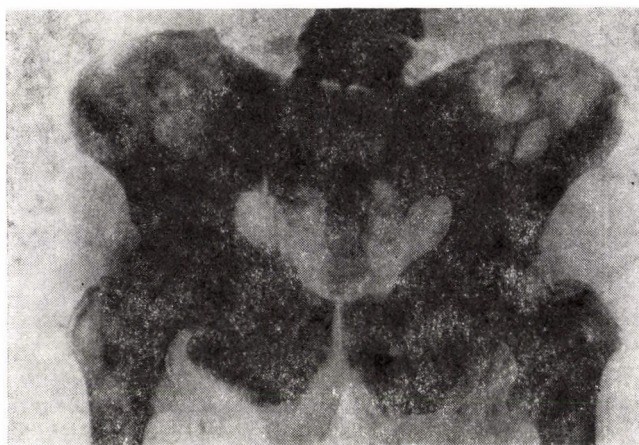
An unambiguously positive bone scintigraphic finding documenting multiple bone metastases (500 MBq ^{99m}Tc -Phosphon is used)
